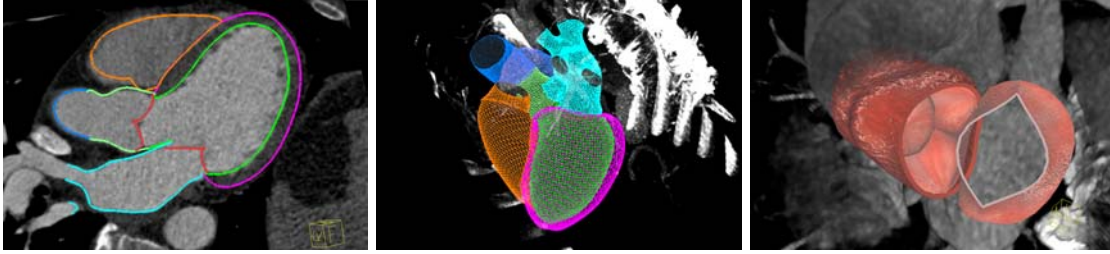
Patient specific cardiac model fitted to 4D CT data with chambers and valve details.
